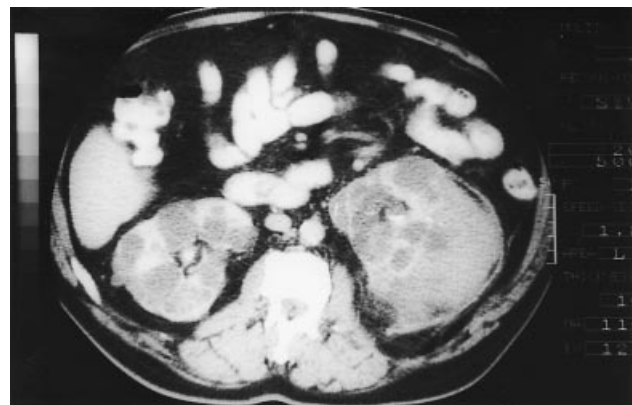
CT abdominal scan. Enlarged kidneys with multiple cystic spaces and left perinephric haematoma.
